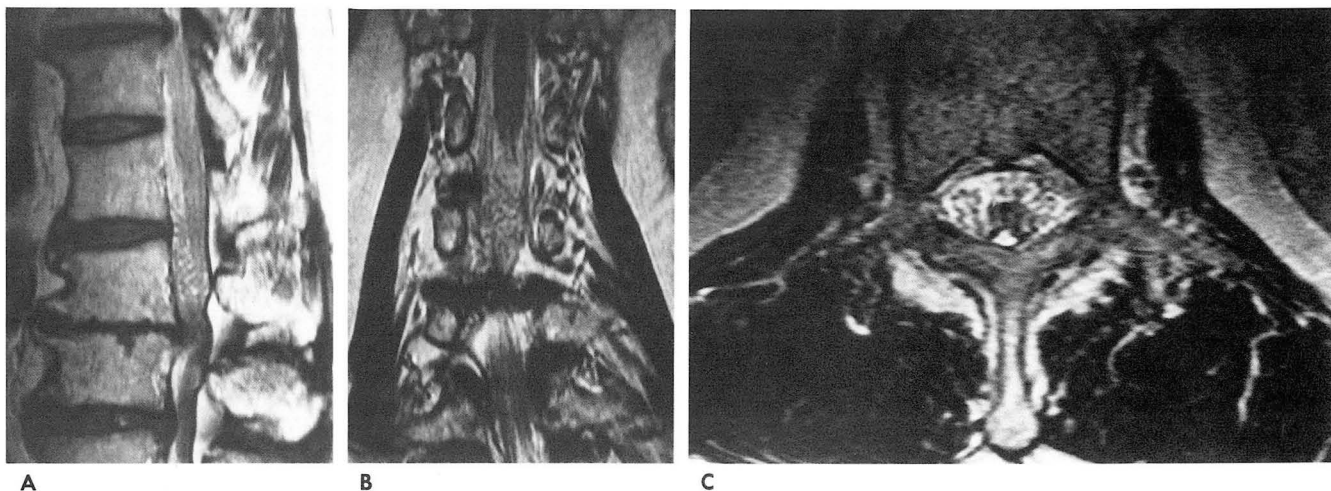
A. T2-weighted sagittal image shows severe spinal stenosis at L2-3, secondary to posterior osteophytes and disc bulging. Severe RNR of the cauda equina are seen above the level of stenosis.
